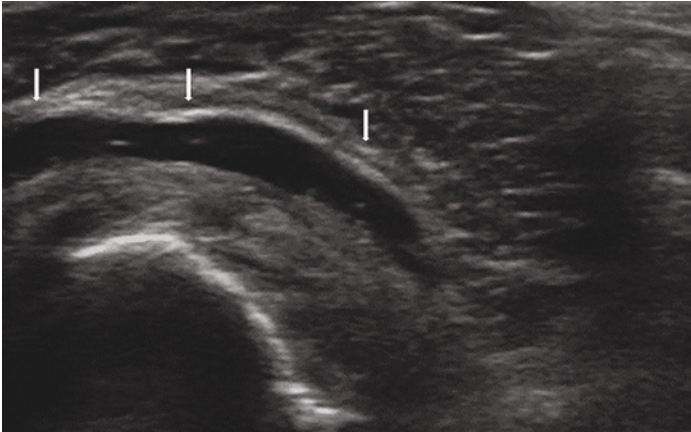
Ultrasound diagnostic scan showing subacromial bursa effusion (white arrows)
